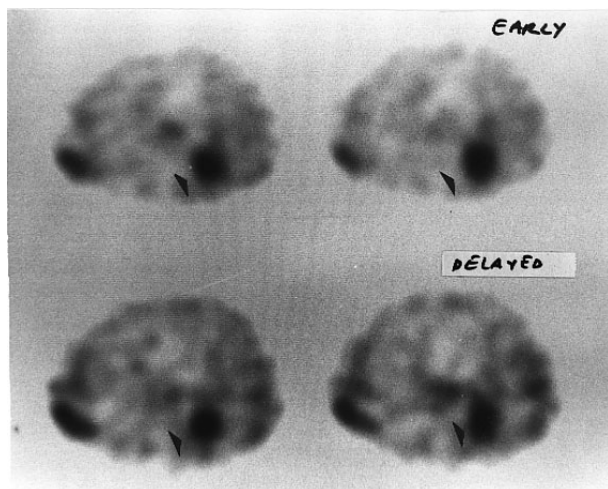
Transverse ^{201}Tl SPECT images of R(+) and p53(+) patient 1 with a tumor (▶) in the left middle lung area: early (upper row) and delayed (below row) images.
